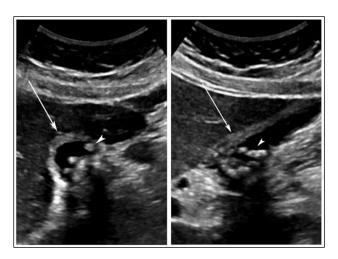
Transverse and long ultrasound views of the gallbladder demonstrating gallbladder wall thickening (arrow) and numerous gallstones (arrowhead).
